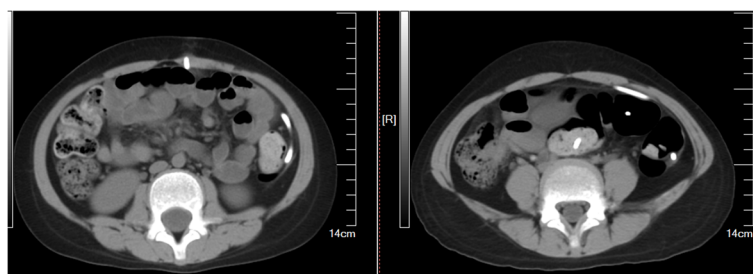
Abdominal computed tomography scan demonstrating the migration peritoneal catheter in the bowel lumen
